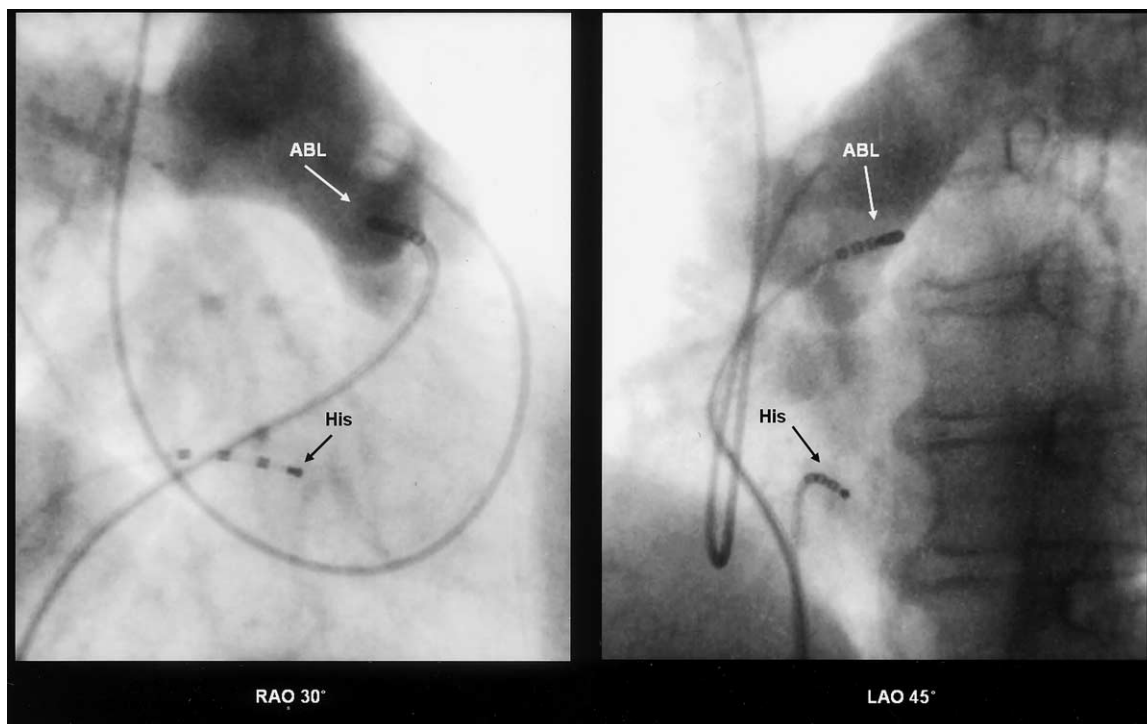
Right (30°) and left (45°) anterior oblique (RAO and LAO, respectively) radiographic views of the ablation catheter (ABL) within the pulmonary artery. Pulmonary arteriogram reveals that the catheter is positioned at the posteroseptal portion of right ventricular outflow tract, which is above the pulmonary valve. Successful radiofrequency application was performed at this site. His = catheter at the region of the His bundle.
